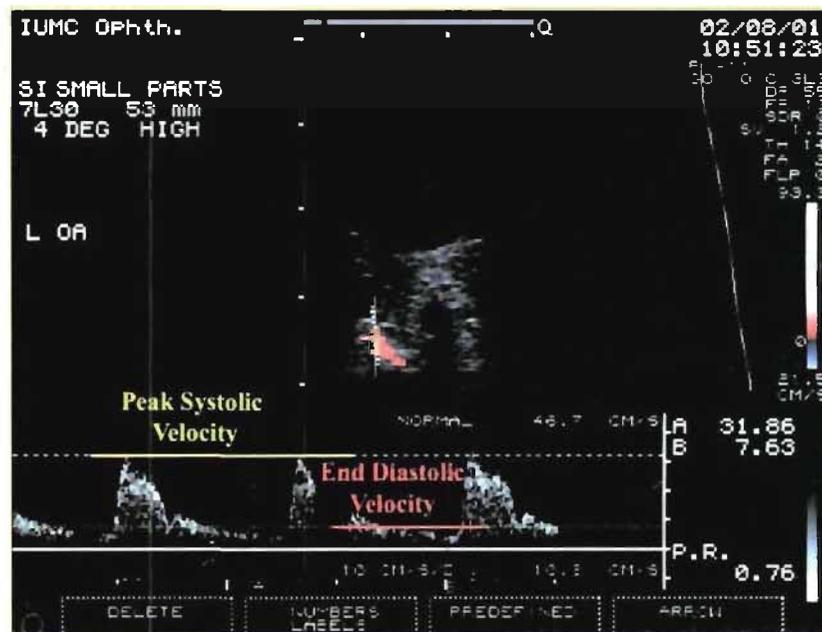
Color Doppler imaging showing peak systolic and end-diastolic velocities in the ophthalmic artery (courtesy Dr Alon Harris)
